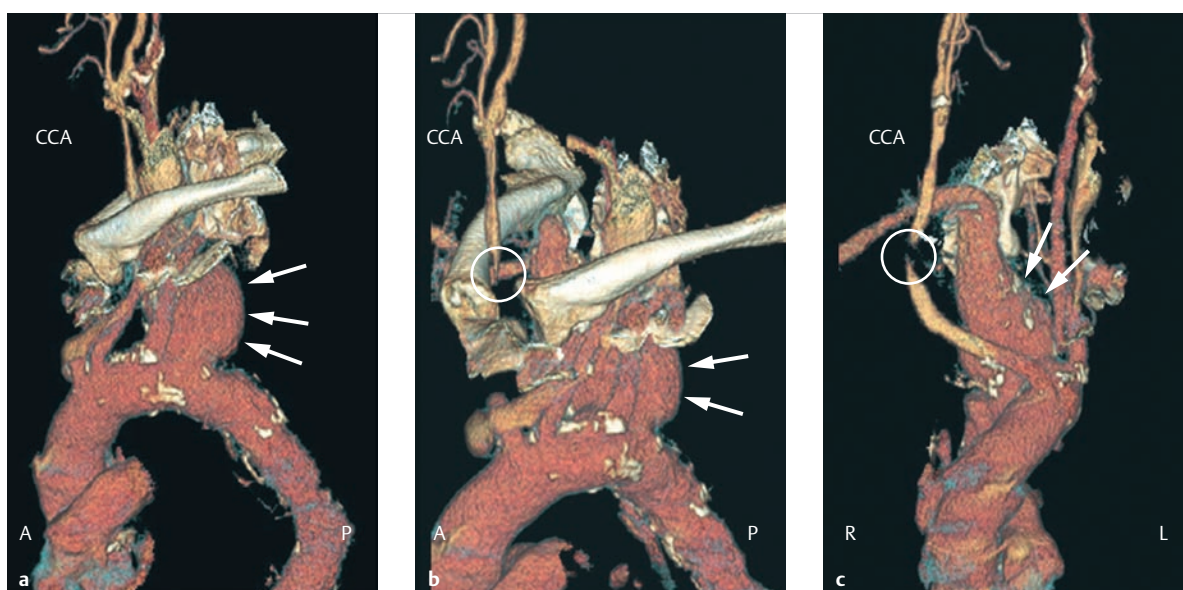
Lusorian artery, Kommerell diverticulum, and carotid artery compression. Fifty-six-year-old female patient, presenting in the emergency room due to acute shortness of breath. The CT depicts a covered, ruptured Kommerell diverticulum (a–c, arrows) causing high-grade stenosis of the trachea and the right carotid artery near the clavicle (b, c, circle). CCA = common carotid artery
